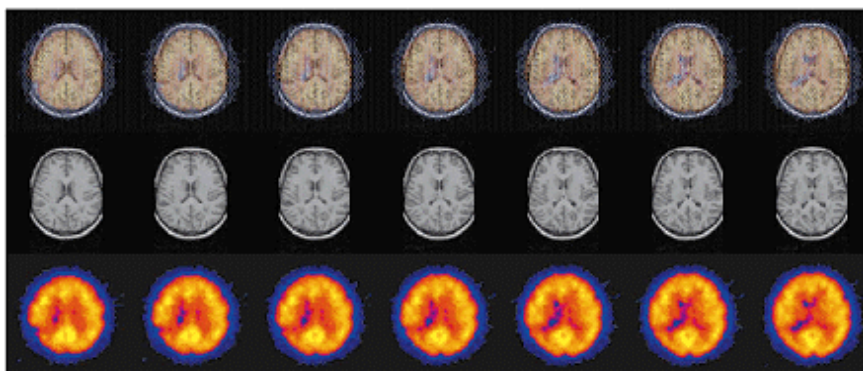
Use of image superpositioning in morphological and functional imaging. Upper row: fused image, middle row: MRT, bottom row: Tc-99m IMPAO perfusion SPECT. (Siemens ICON software).
